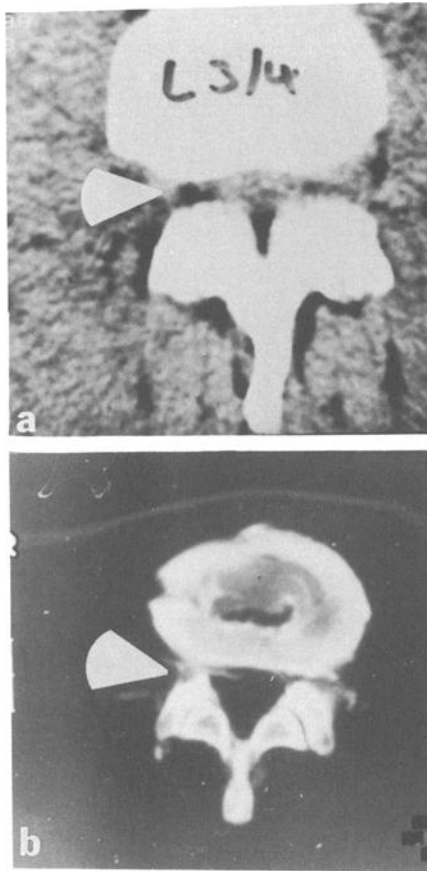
Case 1: narrow lumbar canal, due to short pedicles, on a CT scan image of L3-L4 (a). The postmortem image shows a lumbar canal of normal dimensions. Intrabody disk herniation is clearly seen (b).
